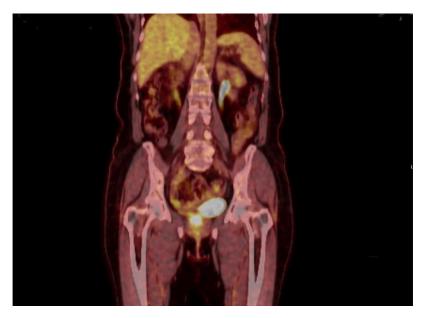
PET/CT image of vaginal metastasis.
